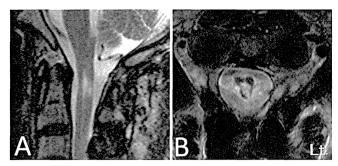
Case 1. Sagittal (A) and axial (B) T2-weighted MR images demonstrating restoration of the spinal cord shape and enlargement of the higher signal intensity region 4 years after surgery.
